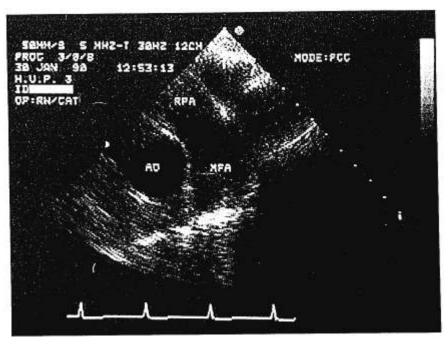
Two-dimensional transesophageal echocardiogram of the main pulmonary artery (MPA) using the basal short-axis view at the level of the aortic root. RPA = right pulmonary artery; AO = aortic root. The emitted ultrasound beam is parallel to blood flow in the MPA.
